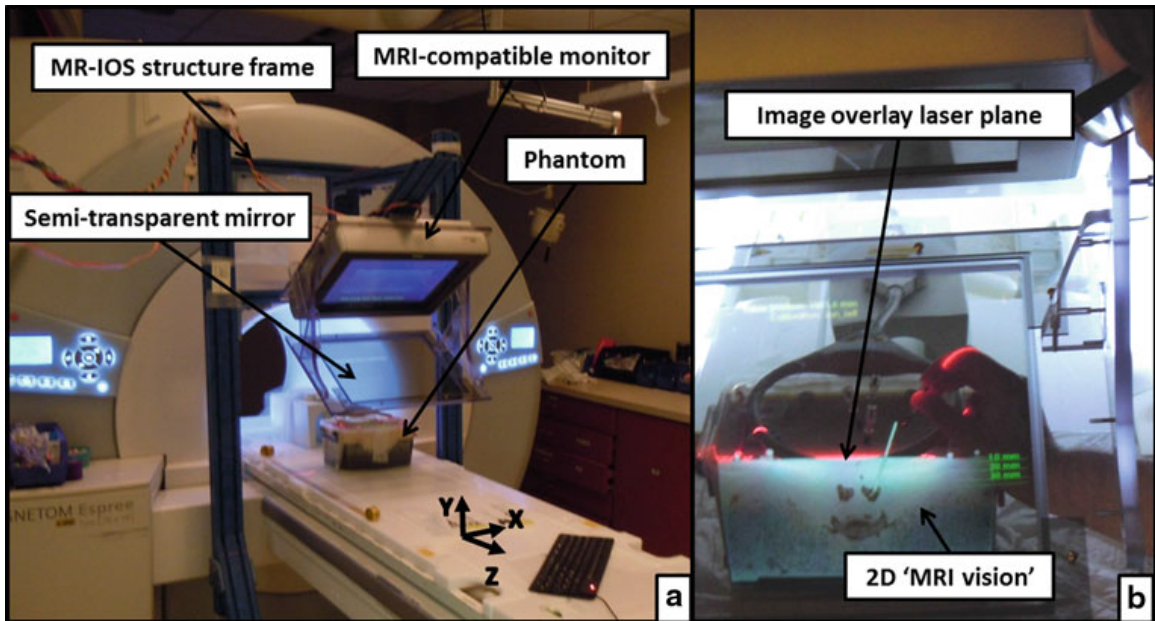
The system components of MR-IOS is shown in (a). Using this system, the surgeon can look through the semi-transparent mirror that is augmented with the insertion path (b). Image courtesy of the International Journal of Computer Assisted Radiology and Surgery, *MR image overlay guidance: system evaluation for preclinical use*, Paweena U-Thainual, Jan Fritz, Choladawan Moonjaita et al., Copyright 2012.
